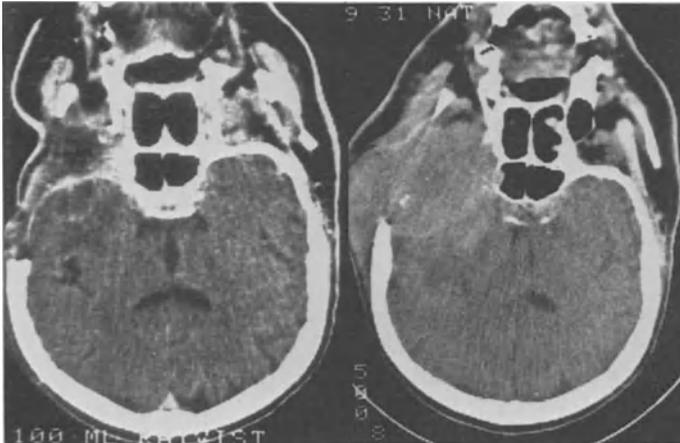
Pre- and postoperative CT scans in coronal sections of a 55-year-old man with metastatic carcinoma of the left temporal and infratemporal region and invasion of the CS and V 1, 2, and 3 compression causing neuralgic facial pain. Tumor removal was limited because of malignancy; residual tumor tissue was left to ensure preservation of the ICA and the IIIrd and IVth cranial nerves. Plastic reconstruction was undertaken with a muscle flap and free epidermis transplant
